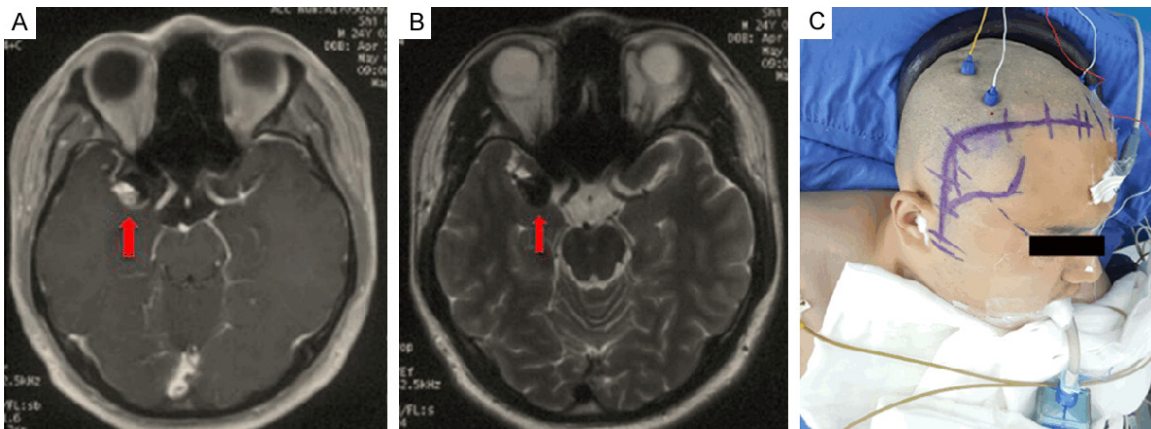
Preoperative T1-MRI (A) showing partial thrombus in the right M1 segment MCA, T2-MRI (B) detecting a round low signal in the right temporal lobe (red arrow) and preoperative preparations (C).
